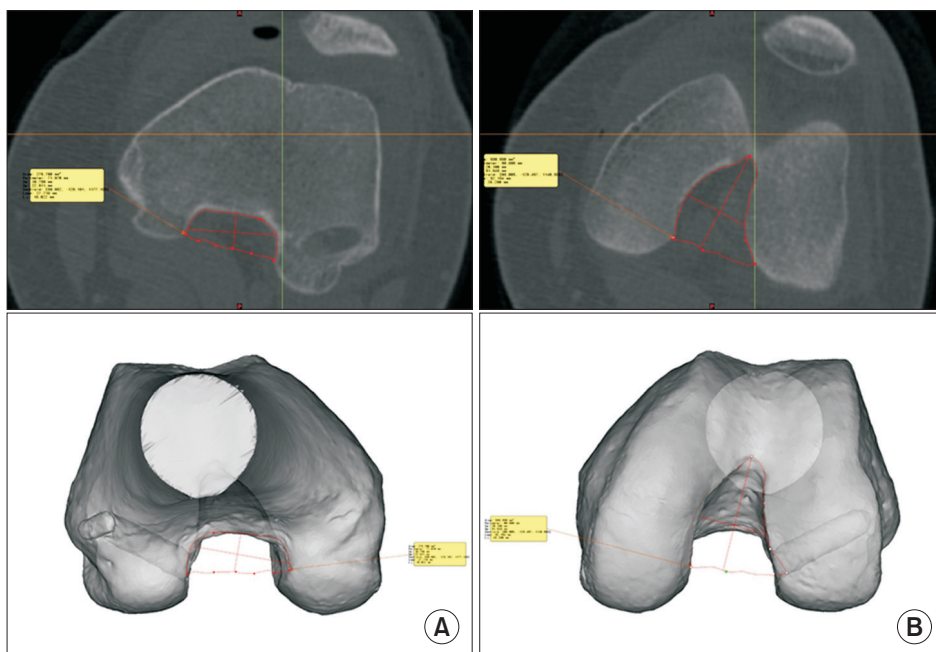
Measurements for the cross-sectional area of the intercondylar notch in the computed tomography images, which are simultaneously reflected in the reconstructed three-dimensional femur model. Measurements at the most proximal (A) and distal (B) levels of the Blumensaat's line correspond to the axial plane perpendicular to the long axis of the distal femur.
